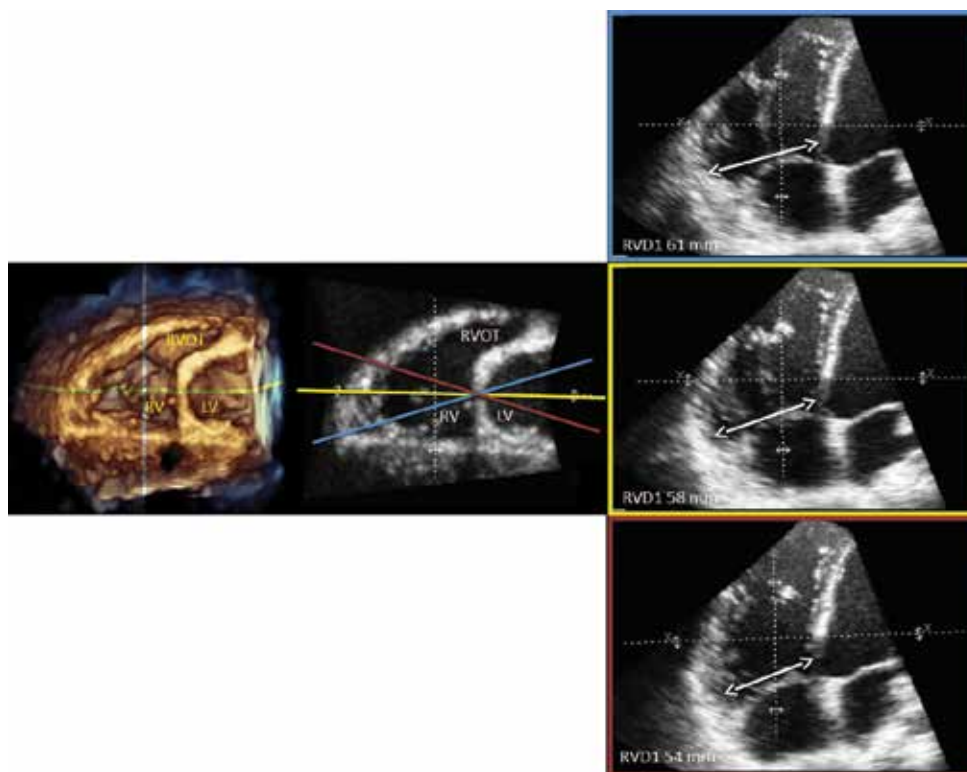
Due to the crescent shape of the right ventricular, minor alterations of the two-dimensional echocardiography apical four-chamber plane orientation shown on the short-axis slices (blue, yellow, and red lines in the central panel) obtained from transversal cut planes of a three-dimensional data set of the right ventricle (RV) seen from the ventricular perspective (left panel) result in significant changes of the RV basal linear dimensions (right panels); LV — left ventricle; RVD1 — right ventricular basal diameter; RVOT — right ventricular outflow tract
